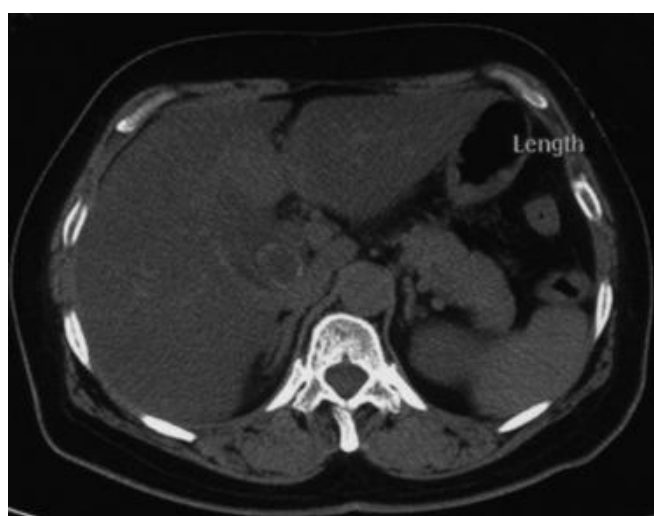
CT image showing gallstone.
